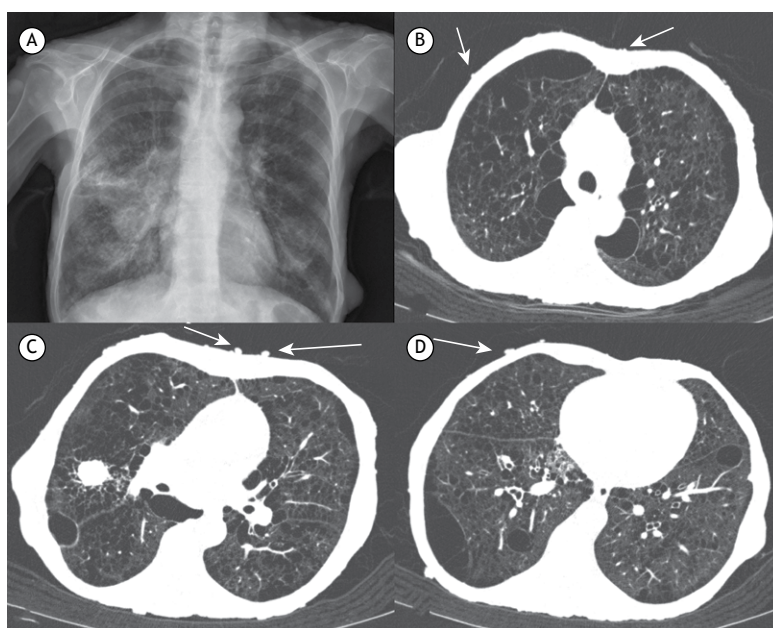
In A, chest X-ray showing an ill-defined opacity in the right lung and mediastinal enlargement, suggestive of lymph node enlargement. Note soft-tissue nodules on the chest wall and shoulders. In B, C, and D, axial CT images of the chest (lung window settings) showing cystic and emphysematous changes predominantly in the upper lobes, as well as a solid nodule with spiculated margins in the right upper lobe. Note nodules (neurofibromas) on the chest wall (arrows).
